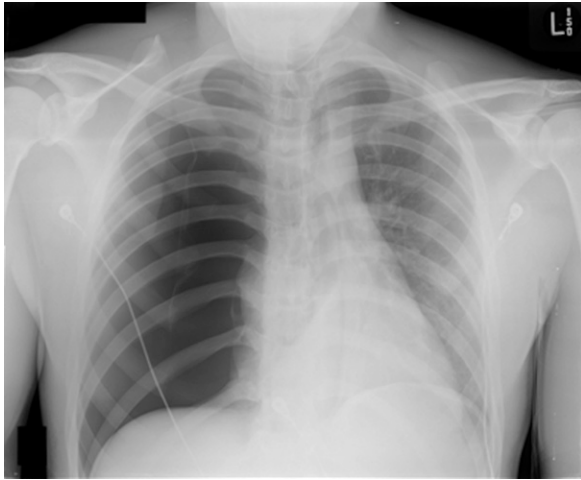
Chest radiograph of tension pneumothorax.
